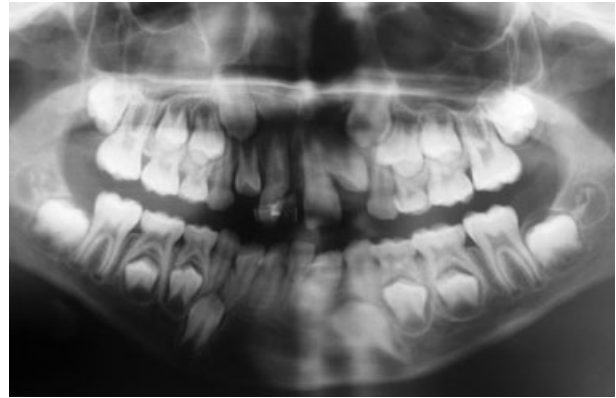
Orthopantomographic view of the patient.
